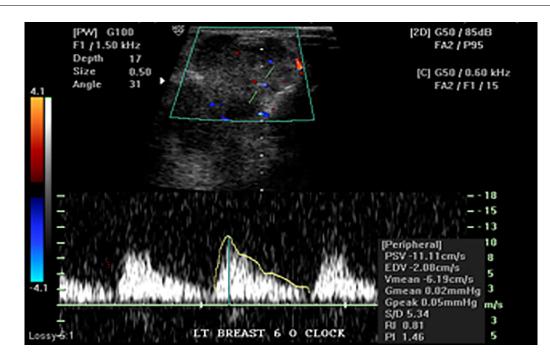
(Patient no. 1): Color Doppler in left breast, at 6 o'clock location shows peripheral vascularity, the pattern is of arterial flow. The RI is 0.8 and PI is 1.47, suggestive of malignancy.
